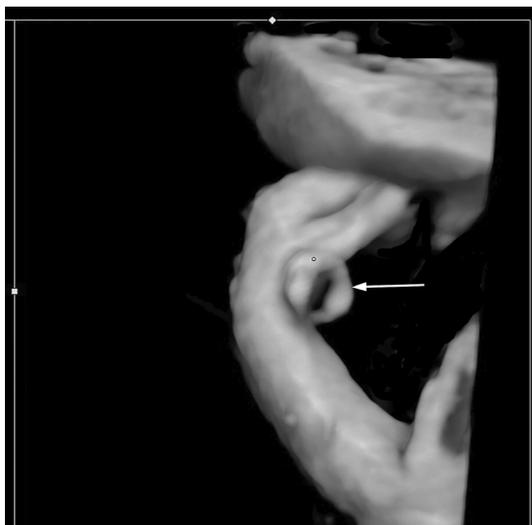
A three-dimensional reconstruction of a shunt extremity (white arrow) surrounded by a fetal arm in a case of a 30+3 week fetus with hydrothorax treated with a thoraco-amniotic shunt laterally inserted. The shunt appeared to be dislocated and tightened in the fetal hand at the follow-up ultrasound scan evaluation.
